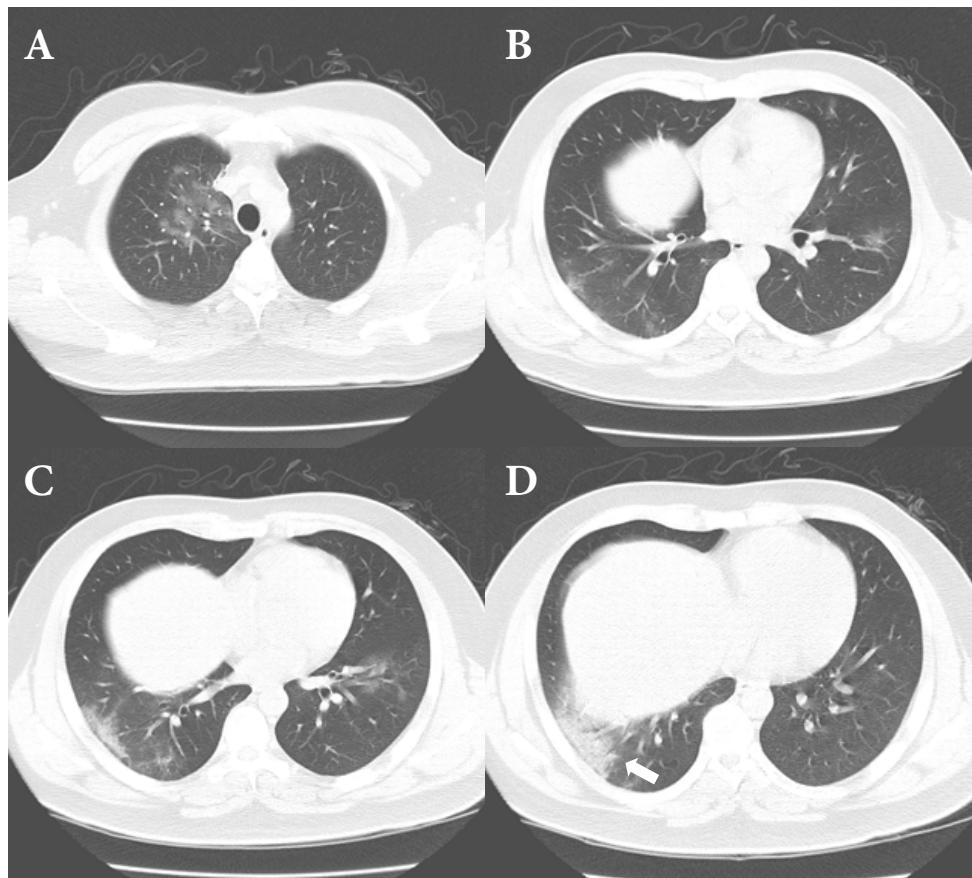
The axial non-contrast chest CT (A-D) shows GGO at both upper lobes and both lower lobes with subpleural consolidation (arrow) at the right lower lobe.
